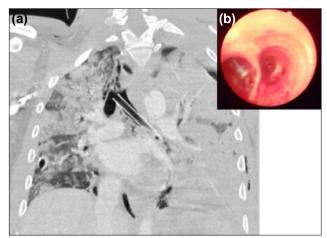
Images of the computed tomography (a) and fiberoptic bronchoscopy (b) revealing a chest drain in the left main bronchus.
